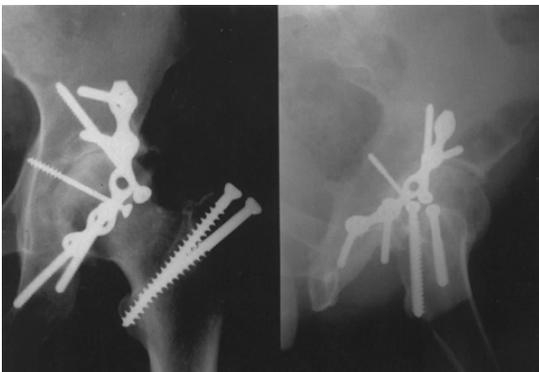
Radiographs taken 6 years after the operation shows progression of degenerative change. The results is rated poor radiographically and clinically.
